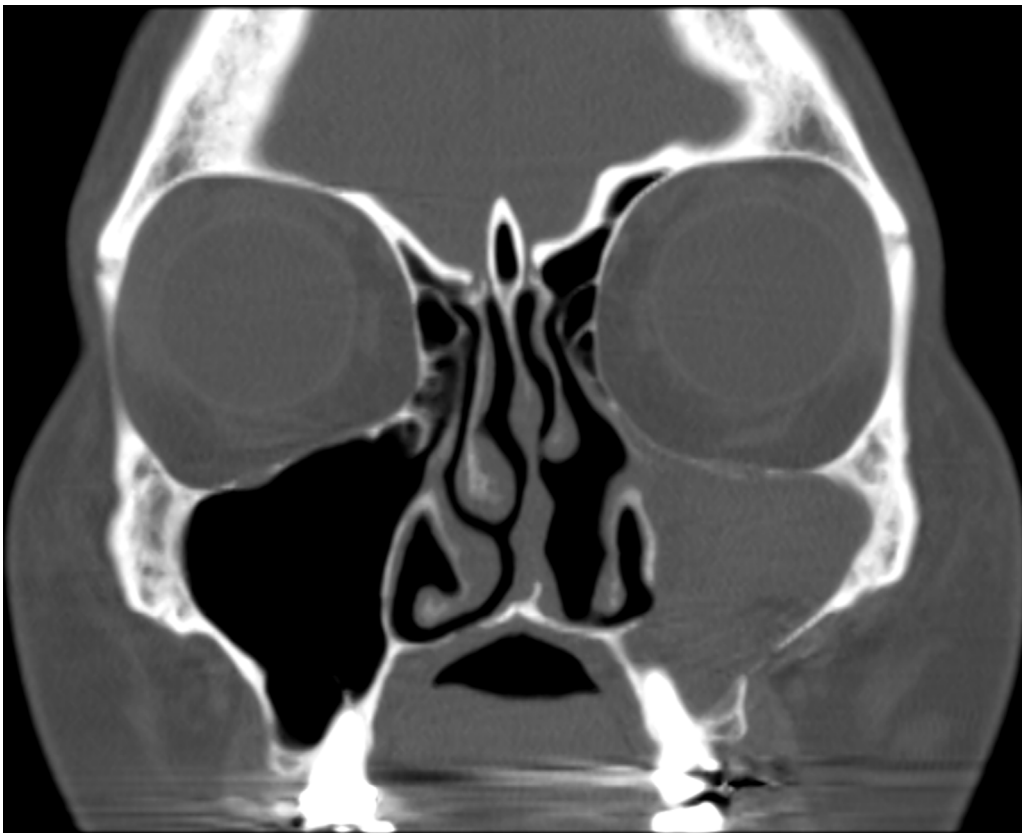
Coronal CT Image of the skull showing complete opacification with hyperdense fluid content of the left maxillary sinus.
